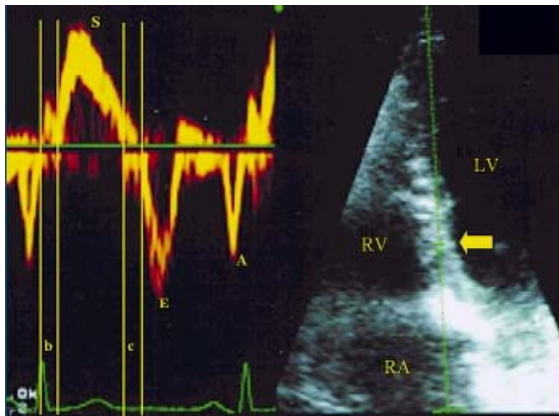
Longitudinal pulsed wave Doppler of the myocardium, 4 chamber view : the sample volume (arrow) is positioned at the basal level of the interventricular septum. ("S"): Systolic phase; ("E"): Rapid filling period; ("A"): Atrial contraction; ("b"): Regional isovolumic contraction time (RIVCT); ("c"): Regional iso-volumic relaxation time (RIVRT); RV: right ventricle; LV: left ventricle; RA: right atrium.
